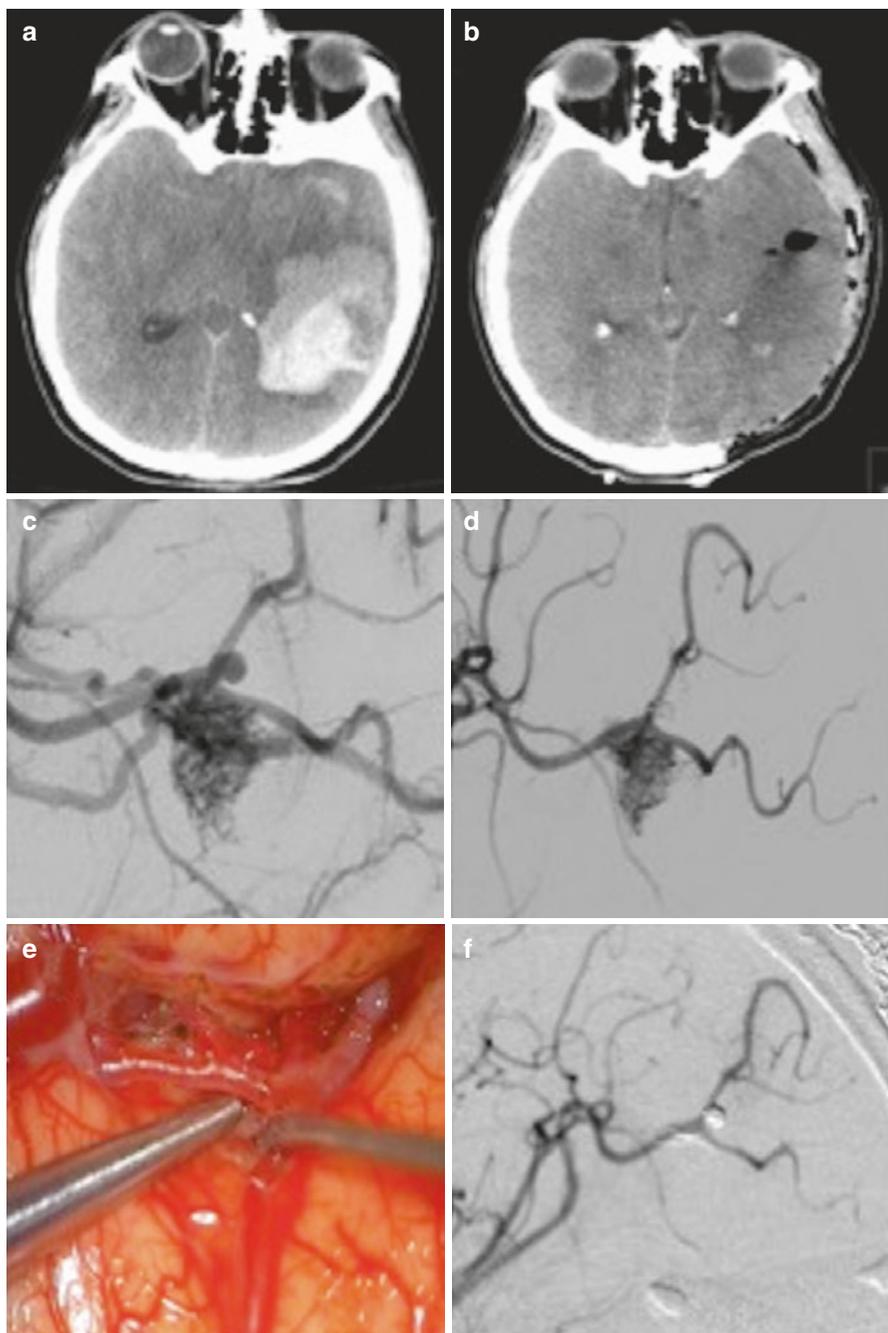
Management of a ruptured left parietal AVM in a 25-year-old male. (a) Presentation CT with radiographic and clinical evidence of herniation. (b) s/p hemicraniectomy with evacuation of hematoma and no resection of AVM. (c) Angiogram showing an aneurysm on the peri-arterial bifurcation. (d) Coiling of aneurysm on POD 1. (e) Following 10 days of observant management, resection of AVM. (f) Intraoperative angiogram showing complete resection of AVM
